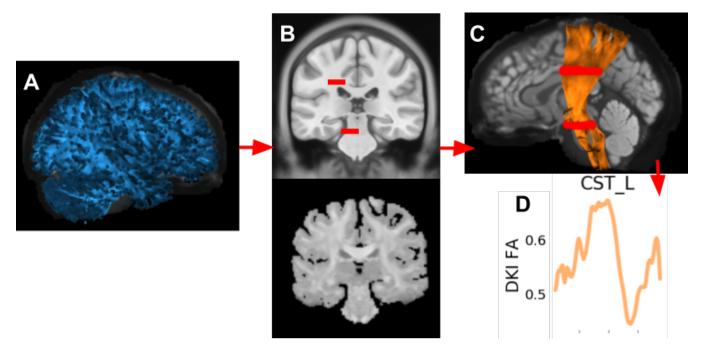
The stages of tractometry. A Computational tractography generates streamlines estimating the trajectories of white matter connections. B An anatomical template is registered to each subjects individual brain. Here, in a mid-coronal view, the MNI T1-weighted template (29, 30), shown with the locations of waypoint ROIs for classification of the left corticospinal tract (5) (slightly enlarged for visualization purposes). The subject's anisotropic power map (APM) (31) is used as the target for registration, due to its similarity to the T1 contrast. C Classification of the streamlines. Here, in a lateral view, the streamlines classified as belonging to the left corticospinal tract (CST L), overlaid on a mid-saggital slice of the subject's non diffusion-weighted (b0) image. The streamlines are shaded by the subject's fractional anisotropy (FA) along their length. D, Tract profiles are extracted from the bundles. Here, the FA profile for CST L.
